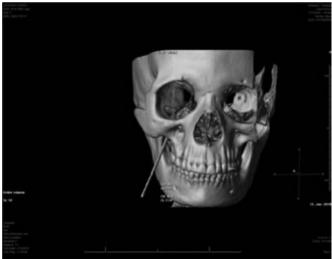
Actual Procedure of CT-guided Neurolysis of Trigeminal Nerve (AP view)
